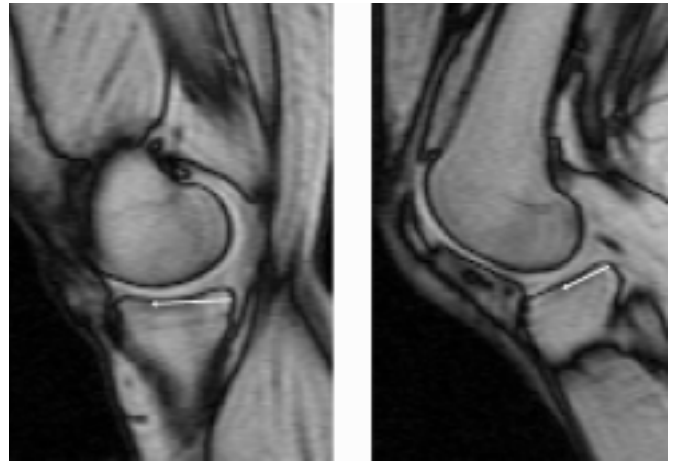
Measurement reference points for tibiofemoral contact mapping. Sagittal MRI images through the medial compartment at 0° and the lateral compartment of the knee at 45°, demonstrating the posterior edge of the tibial cortex and the contact point of the femoral condyle (arrows).
